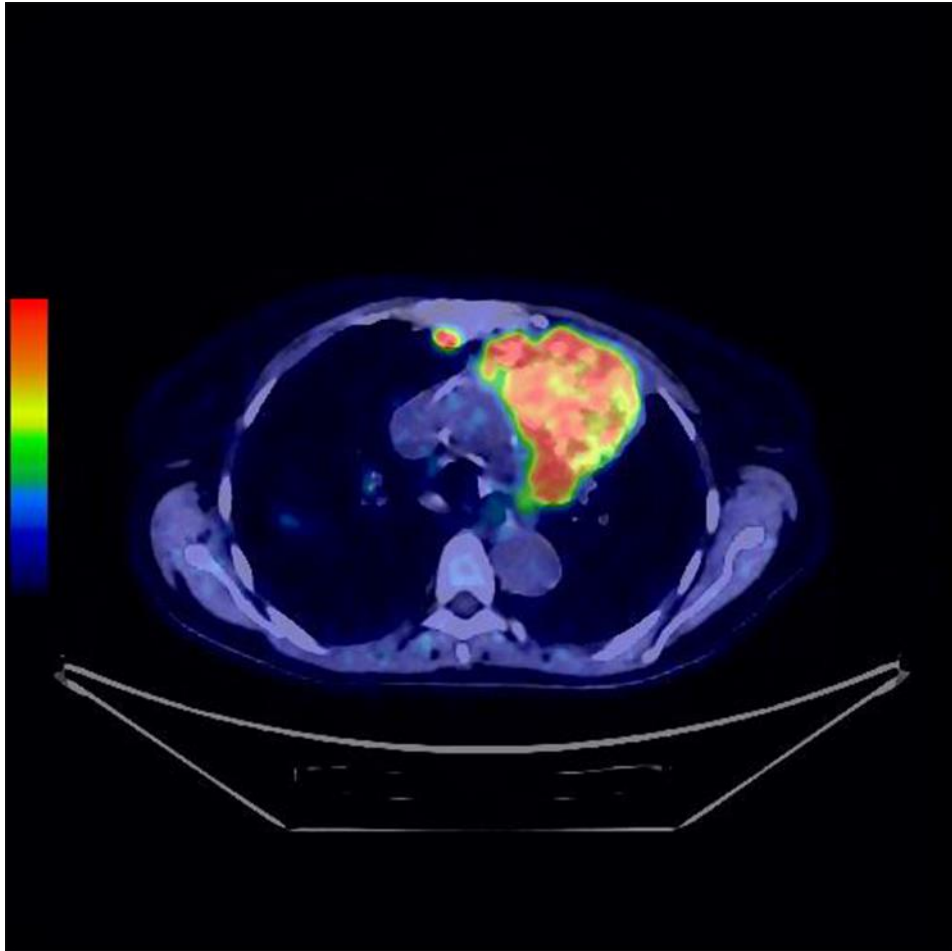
$^{18}\text{F}$ -FDG -PET scan of medullary thyroid carcinoma
